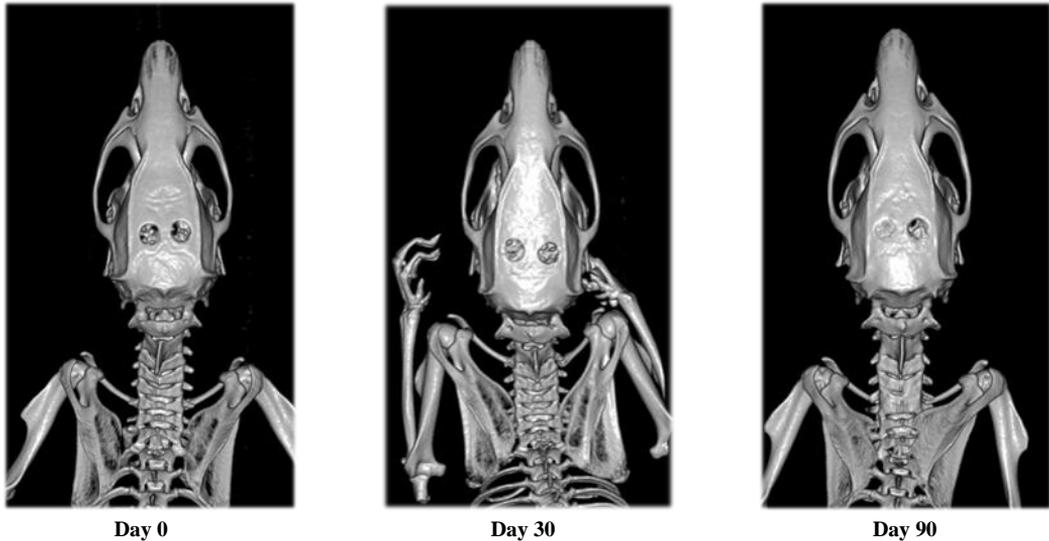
3D CT scans of calvarial bones on days 0, 30 and 90.
